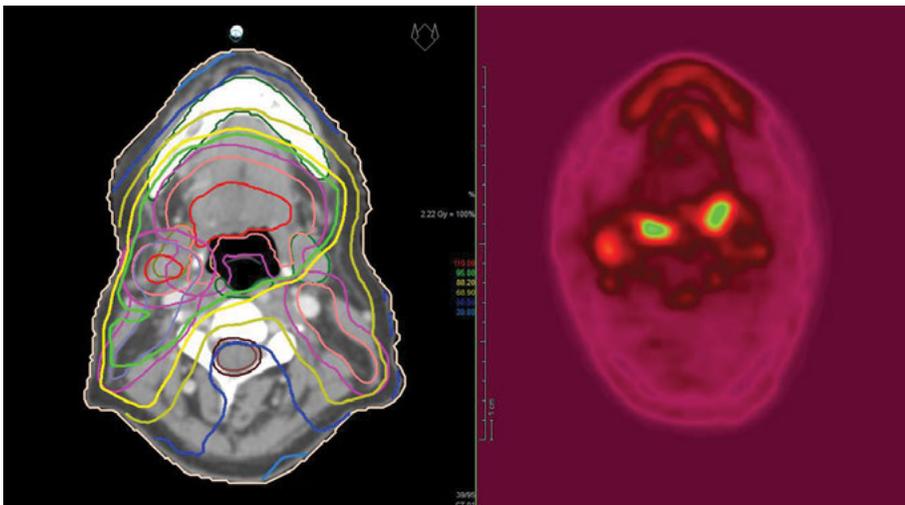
FDG-PET/CT sections from treatment planning. The enlightheten areas represents the tumour and the metastases. Isodoses are
